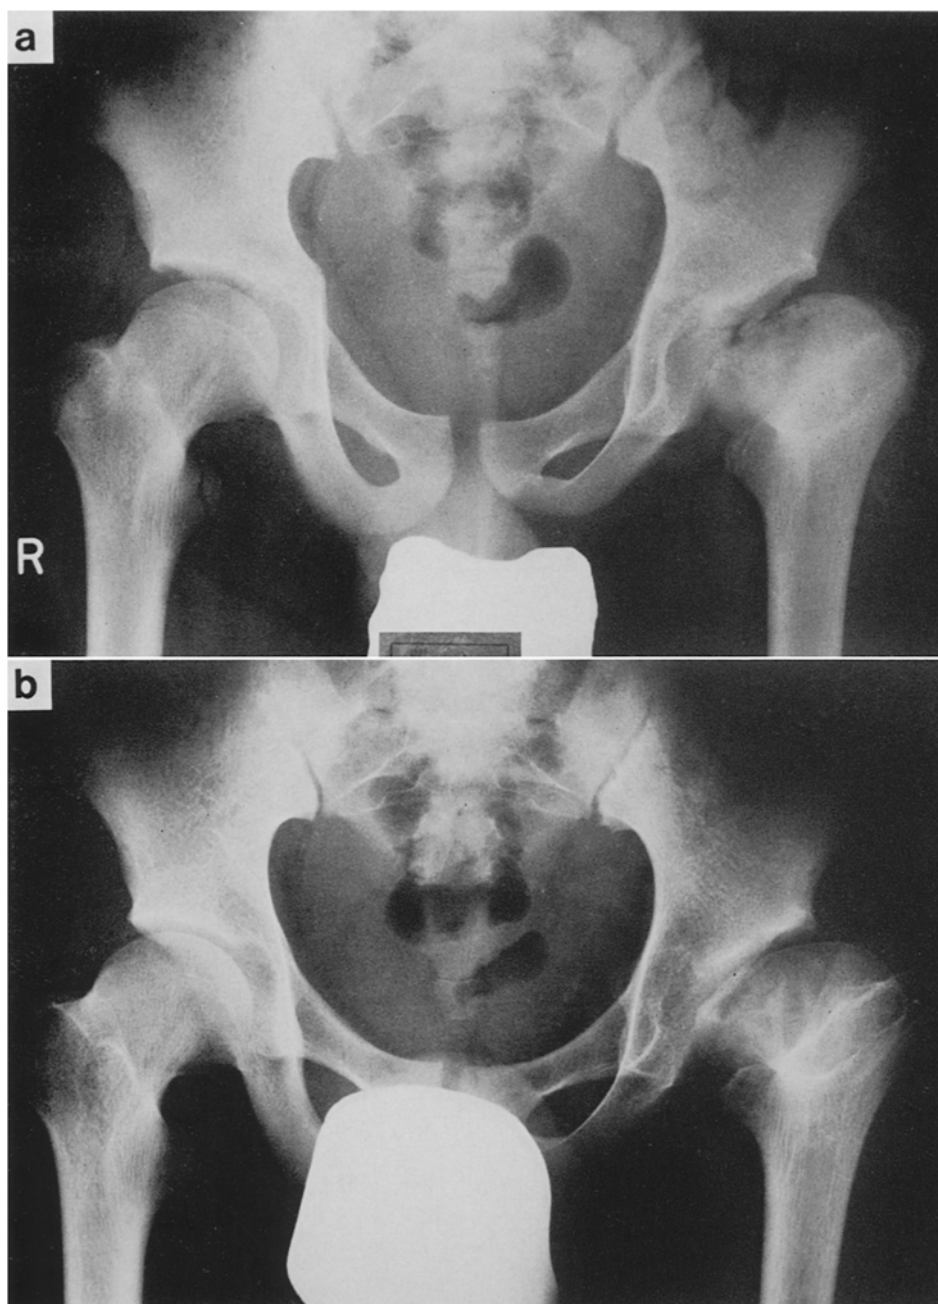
Antero-posterior roentgenograms of the hip joints showing Pethes-disease-like bone change in the left hip joint.
